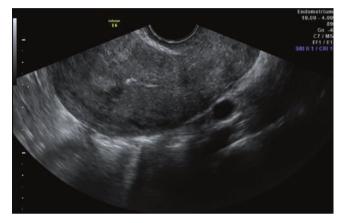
Ultrasound of adhesions after first trimester curettage
